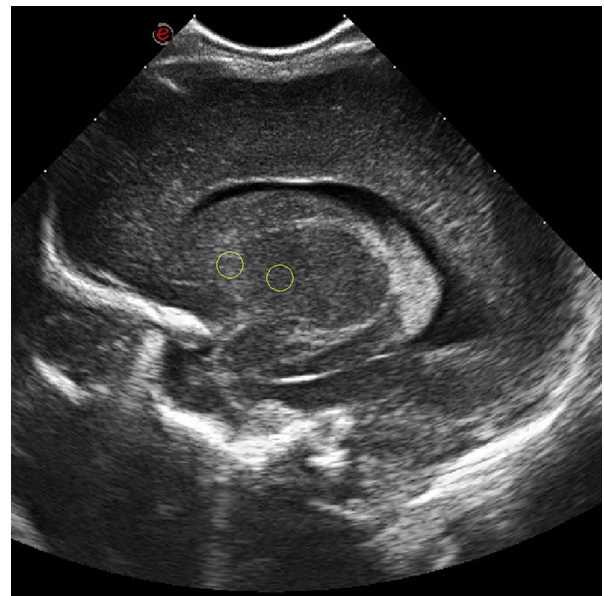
Parasagittal ultrasound image through the anterior fontanel, containing two ROIs in the same time gain compensation segment. From the left to the right: putamen and globus pallidus. ROIs = regions of interest.
